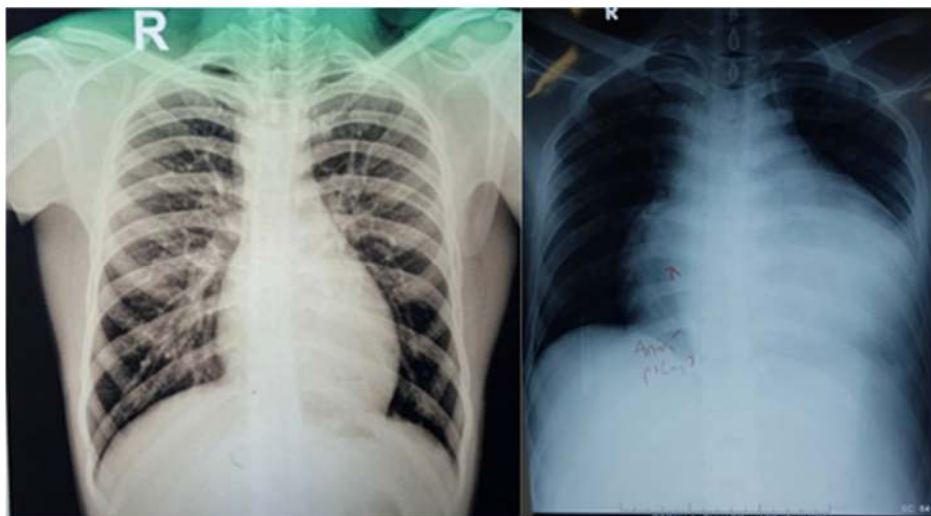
Chest X-ray showed significance difference between before and after COVID-19 infection
